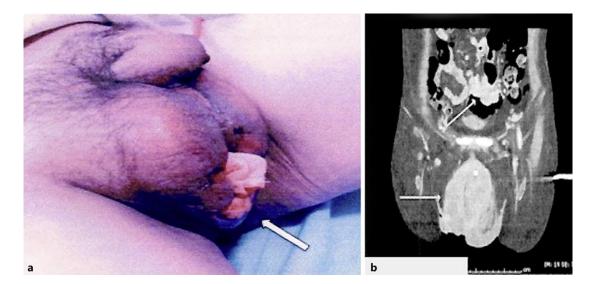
a Necrotic scrotal wound with an exposed fungating mass. b CT of the abdomen/pelvis demonstrating a multiloculated scrotal mass and a sigmoid mass.
